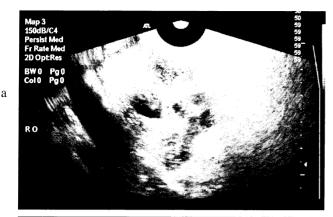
2a. Abdominal ultrasonographic appearance of a tubo-ovarian abscess on the left, with the presence of fluid in the cul-de-sac. 2b. The tubo-ovarian abscess is imaged with irregular internal confines and diaphragms. 2c. The same case with transvaginal ultrasonography.
